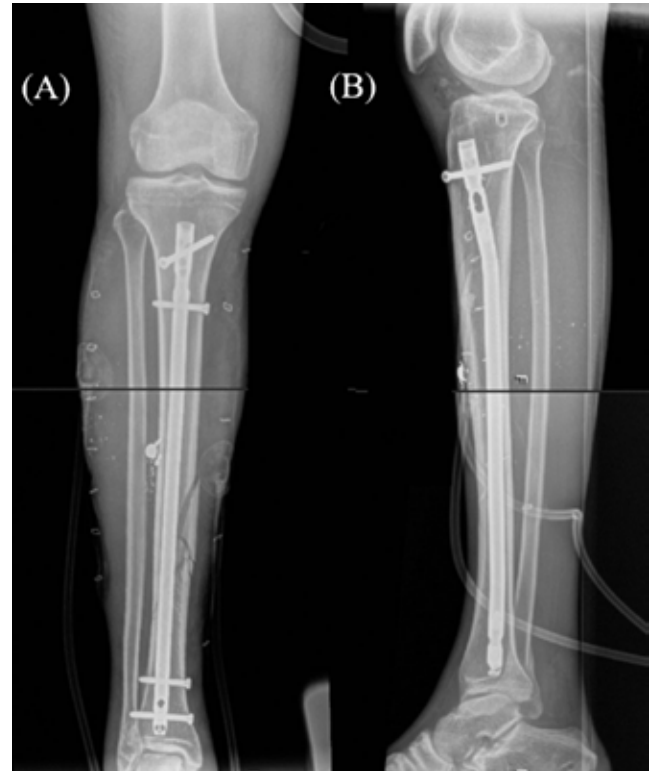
Immediate postoperative (A) AP and (B) lateral radiographs of the tibia IMN showing adequate length, alignment, and rotation at the fracture site. Traveling tibia traction has been removed.
